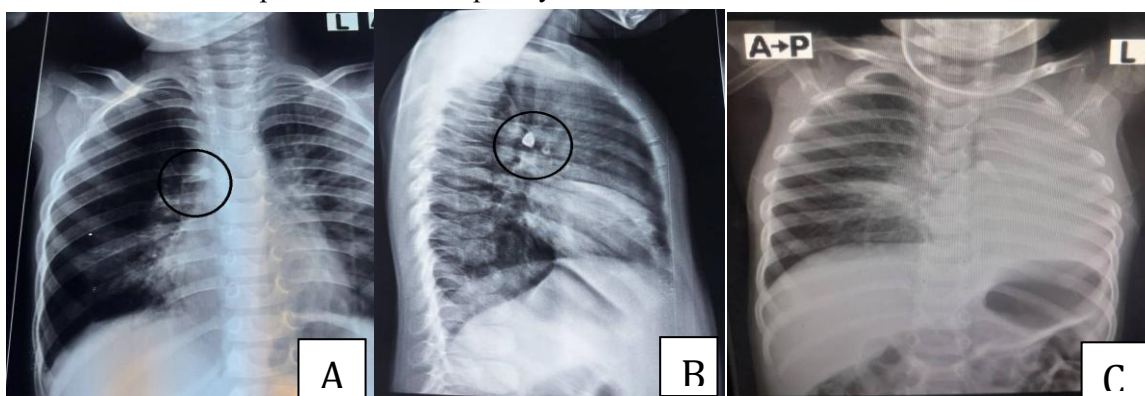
(A) Anteroposterior Chest radiographs showing a radiopaque tooth in the left main bronchus. (B) Lateral view showing associated left-sided opacity and reduced aeration indicating post-obstructive atelectasis. (C) Follow-up showing persistence of the radiopaque tooth within the left main bronchus, with worsening left lung collapse and increased opacity consistent with obstructive atelectasis.
